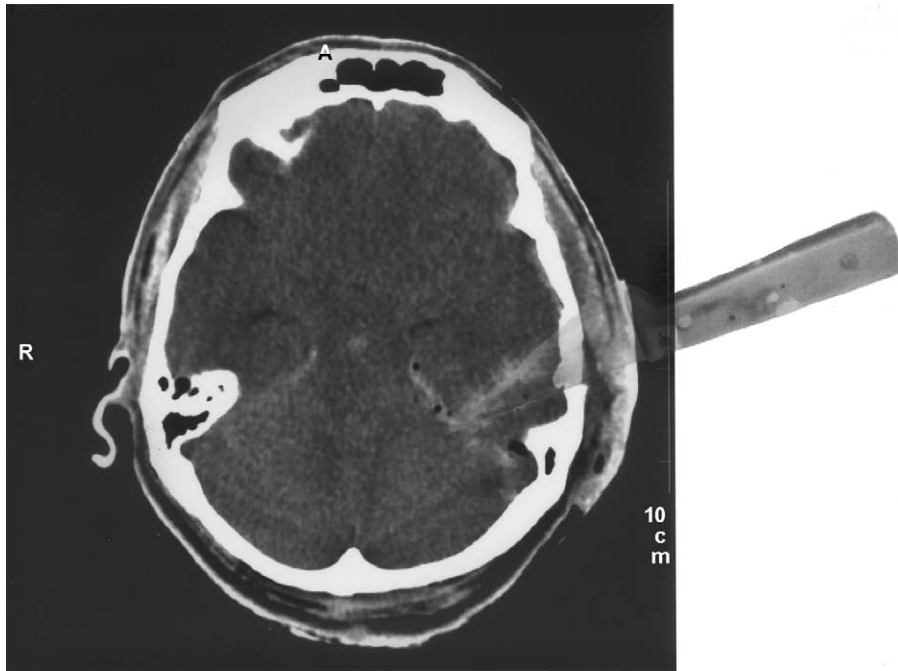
Same CT scan as in Fig. 2. A digital image of the weapon used in the assault was superimposed to show correspondence of the wound tract with the dimensions of the blade.
